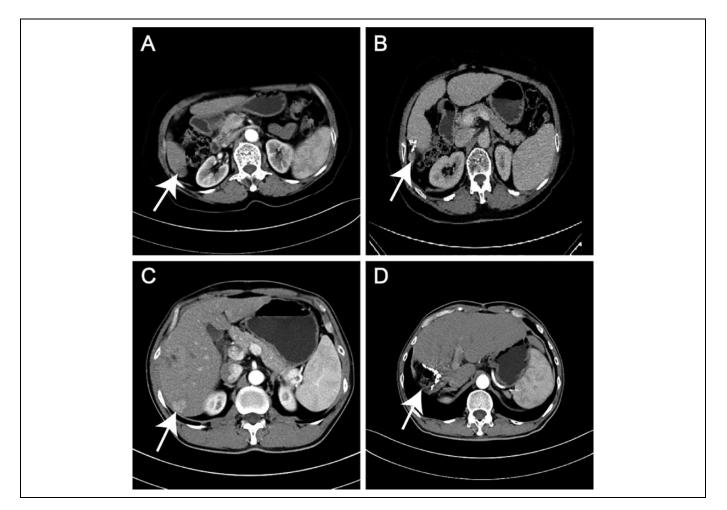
A, Perioperative contrast-enhancement CT showing a tumor of approximately 2×2 cm (a 65-year-old female patient with HCC). B, Follow-up CT 6 months after liver resection without MWA. C, Perioperative contrast-enhancement CT showing a tumor of approximately 3.6×3 cm (a 50-year-old male patient with HCC). D, Follow-up CT 6 months after MWA-assisted liver resection. CT indicates computed tomography; HCC, hepatocellular carcinoma; MWA, microwave ablation.
